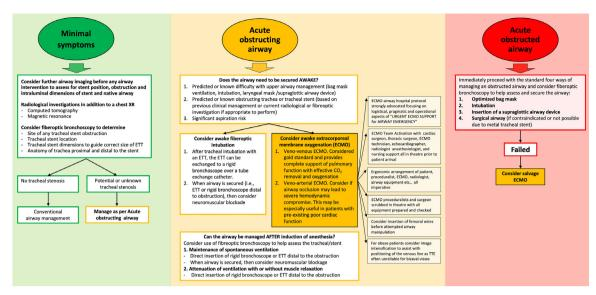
The proposed airway management algorithm of airway obstruction for a patient with a tracheal stent. ECMO, extracorporeal membrane oxygenation; ETT: Endotracheal tube; TTE, transthoracic echocardiogram; XR, x-ray.
